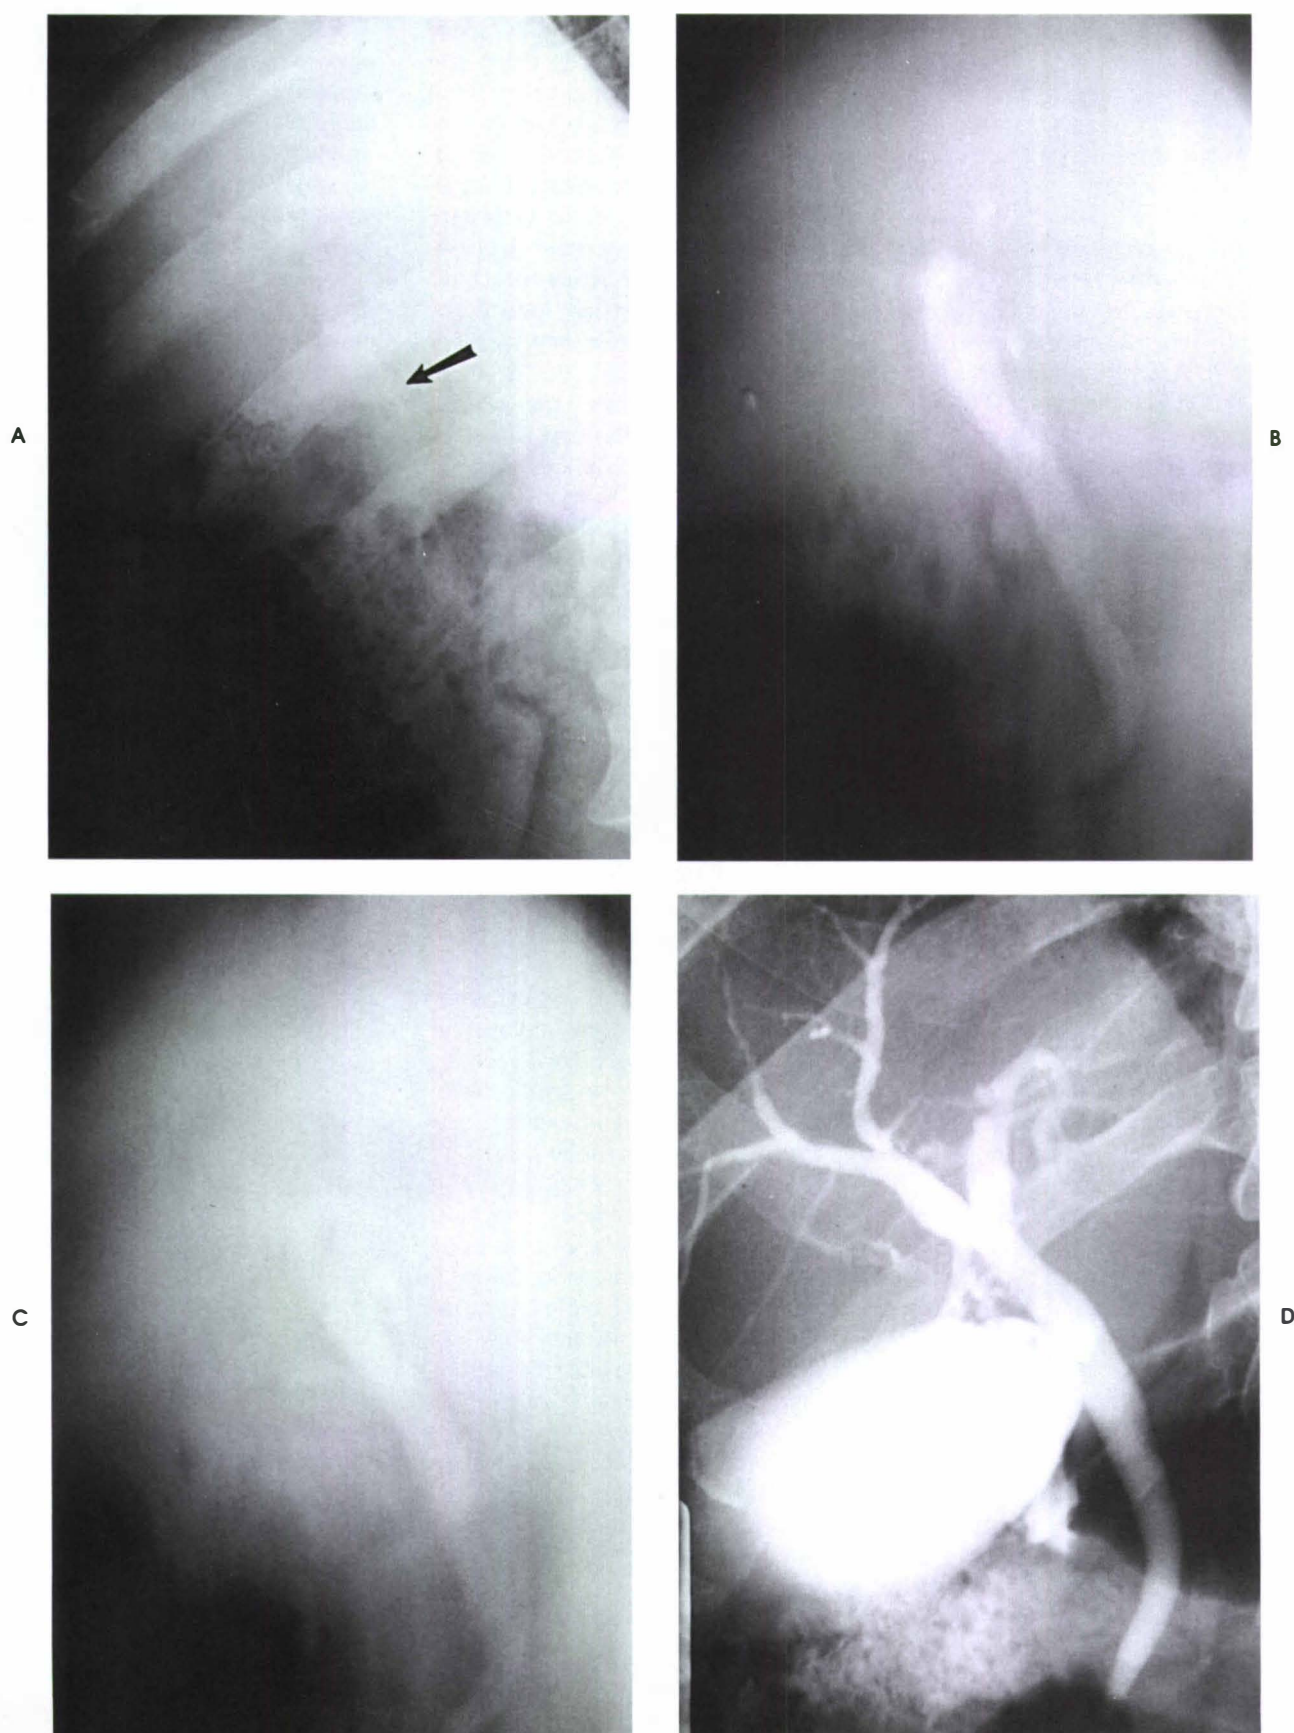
A, IVU, AP abdomen radiograph. Bowel shadows obscure kidneys. B, AP tomogram of same patient as in A, obtained through midplane of kidneys using 8-degree circular motion. Bowel shadows are absent, and compared with C, visualization of kidneys is improved. C, AP tomogram of same patients as in A and B and at same levels as in B, but employing 20-degree linear motion. Note linear streaking and loss of detail of collecting systems and kidney borders.
